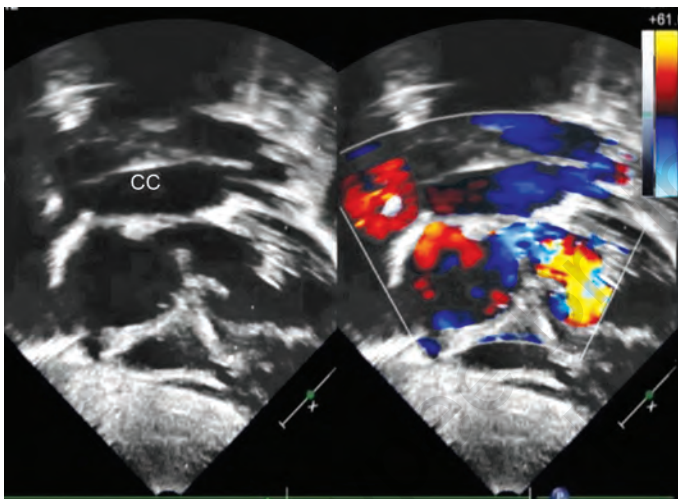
TAPVC: Apical four-chamber (inverted view) showing a common chamber behind the LA.
